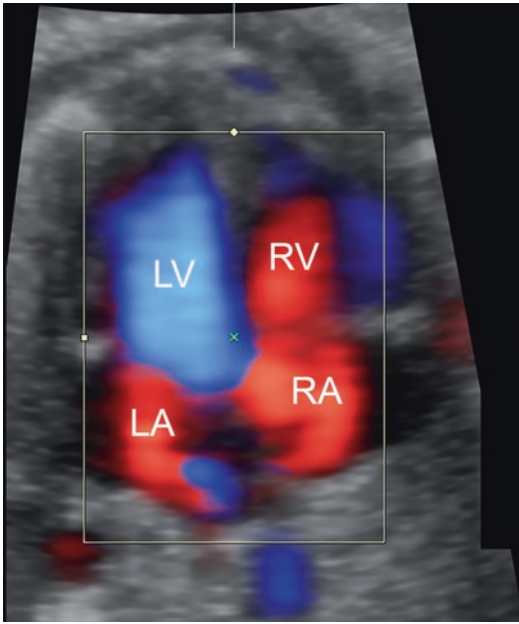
The color Doppler superimposed on the grayscale image of the 4-chamber view obtained from a mechanical STIC acquisition. Because of the low volume frame rate, the systolic flow (blue image in the LV) is superimposed on the image in which diastolic flow is indicated (red). LV left ventricle, RV right ventricle, LA left atrium, RA right atrium
